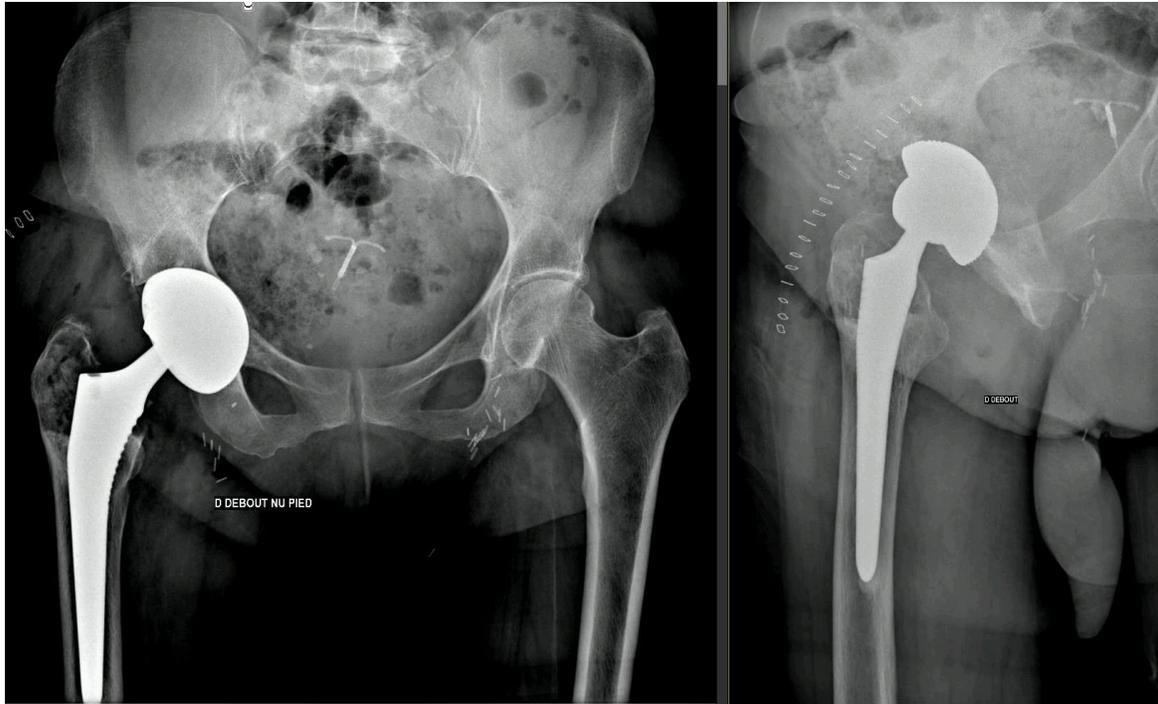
Postoperative anteroposterior pelvic and lateral right hip radiographs, 2024.
